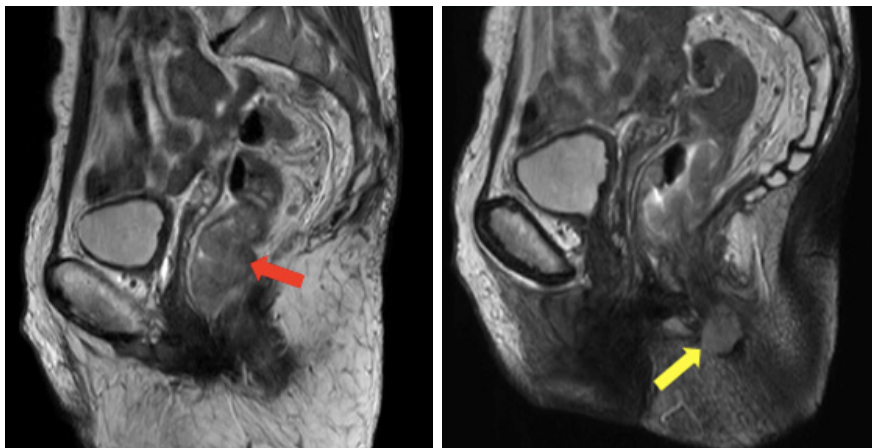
Abdominopelvic MRI weighted in T2, sagittal sections, showing the rectal tumor of the lower and mid-rectum (red arrow), irregular in shape, showing intermediate signal on T2 and the anal mass (yellow arrow) showing the same signal characteristics.
